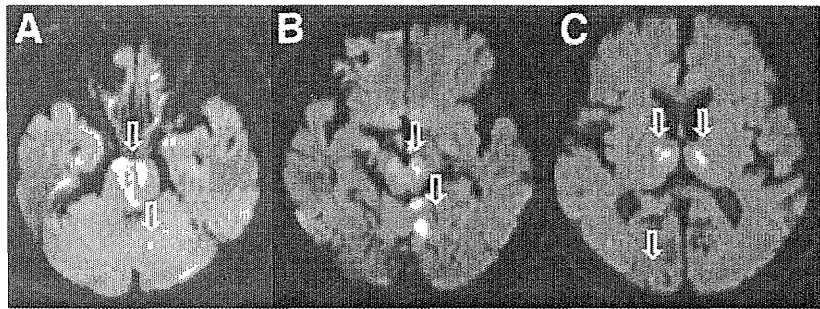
Example of a patient with basilar artery occlusion with diffusion-weighted imaging revealing early ischemic changes in the pons (arrow; 2 points; A), left cerebellum (arrow; 1 point; A and B), midbrain (arrow; 2 points), right posterior lobe (arrow; 1 point; C), and bilateral thalamus (2 arrows; 1 + 1 = 2 points; C) infarction. The posterior circulation Acute Stroke Prognosis Early Computed Tomography Score on diffusion-weighted imaging was 2.
